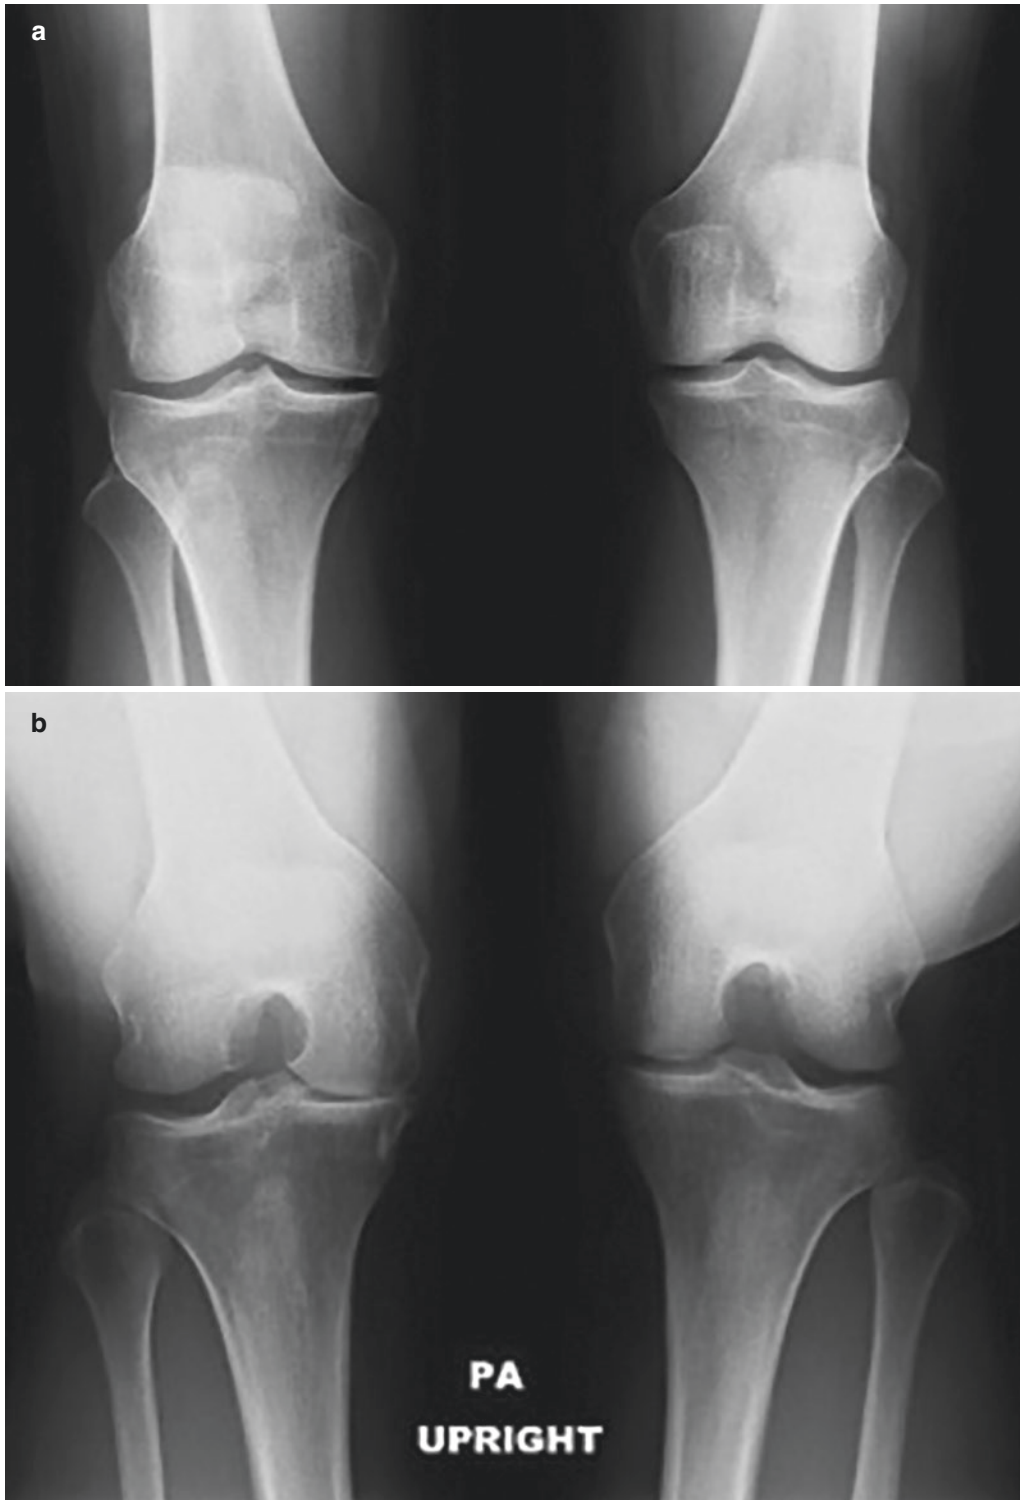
Radiographs showing the importance of the flexion weight-bearing view in the same patient. (a) AP weight-bearing view showing maintenance of joint space.
